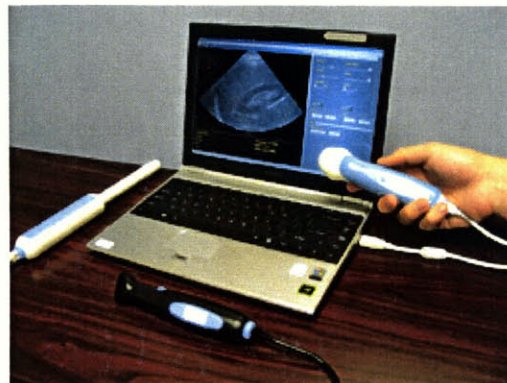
Interson SeeMore Ultrasound Imaging Probes (42)
